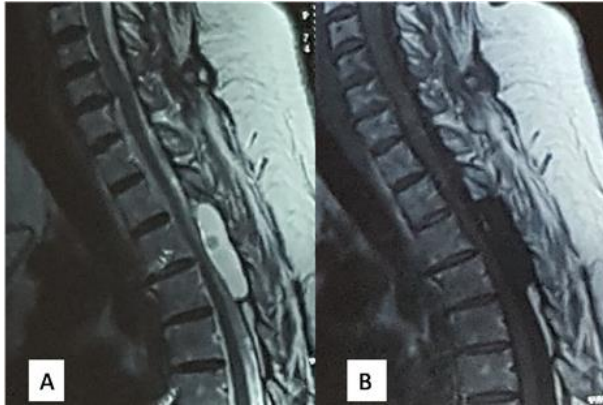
Pre-operative spinal MRI shows a cystic lesion extending from lower edge of T2 to lower edge of T4 with hyper intense signal on T2-weighted MRI accompanied by a central hypo intense signal (A), hypo intense signal on T1-weighted MRI (B).
